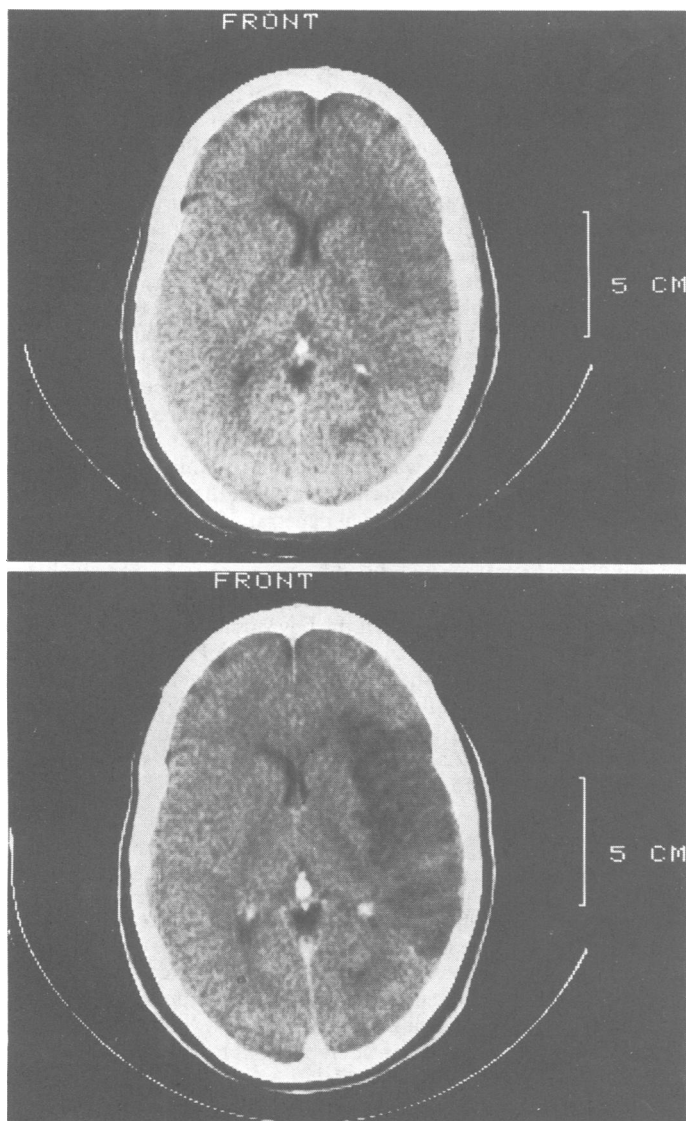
Computed tomogram within two days of cerebral infarction (top), which had become more obvious two weeks later (bottom). The late scan is unlikely to be confused with a resolving haemorrhage because the low density area is large and in the distribution of the right middle cerebral artery.
